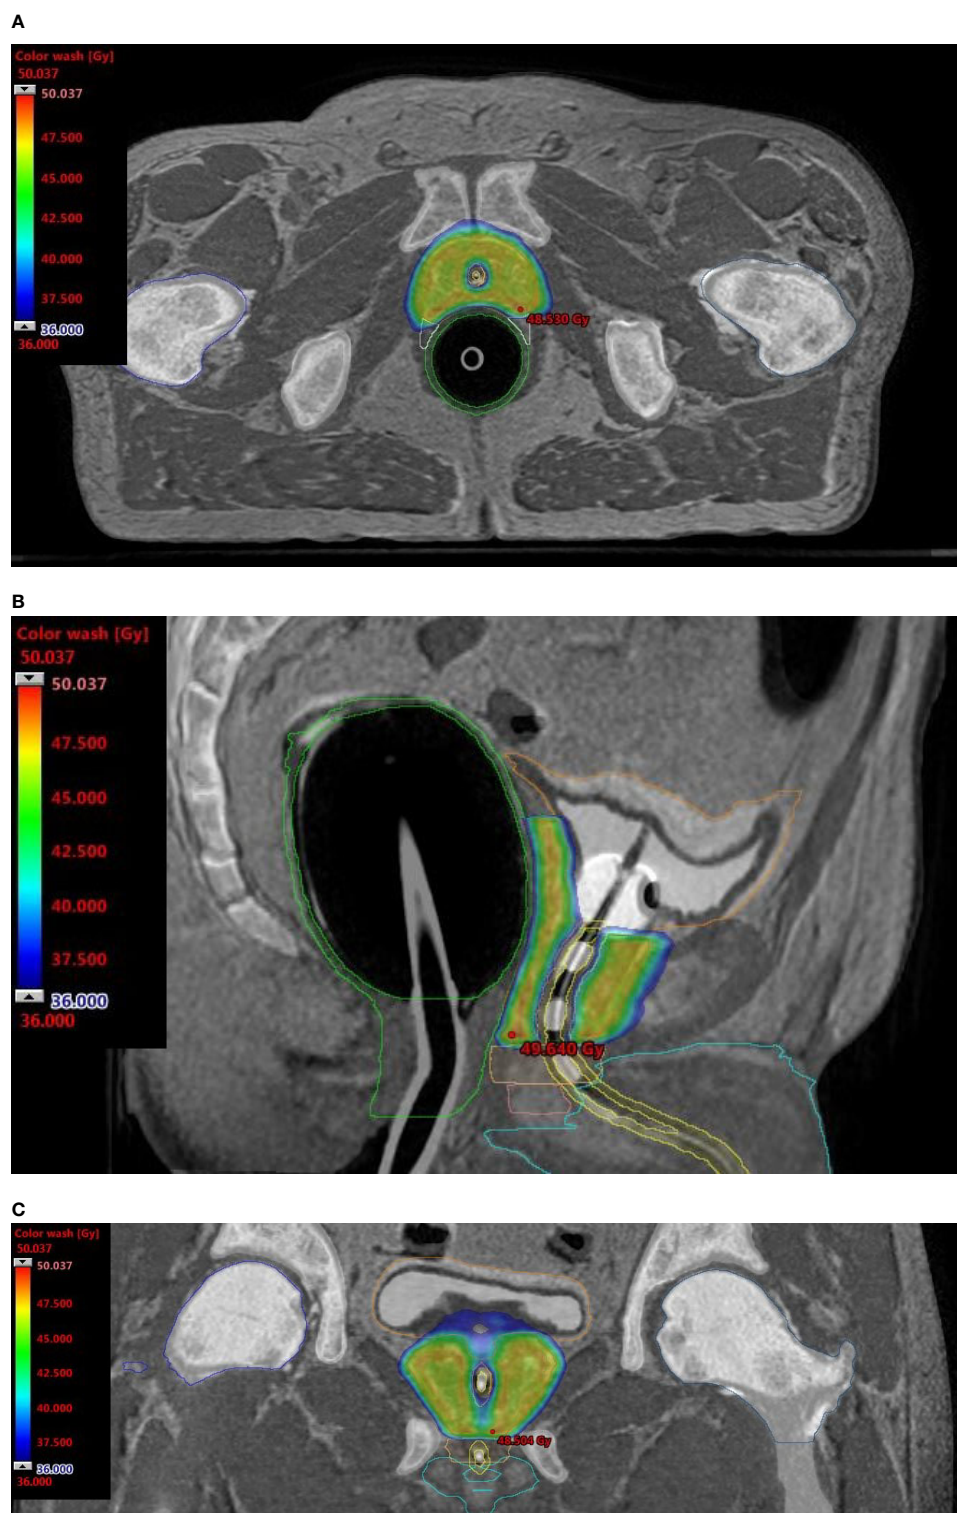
Dosimetric plans of a patient treated with rectal distension-mediated 5×9 Gy extreme hypofractionated SABR. Fused CT-MR image sets show dose-sculpted distributions along the urethra, rectal wall, urogenital diaphragm, and neurovascular bundles. Color-wash dose distributions are shown on the axial (A), sagittal (B), and coronal (C) planes. An intraurethral Foley catheter loaded with 3 beacon transponders is visible on the longitudinal plane.
